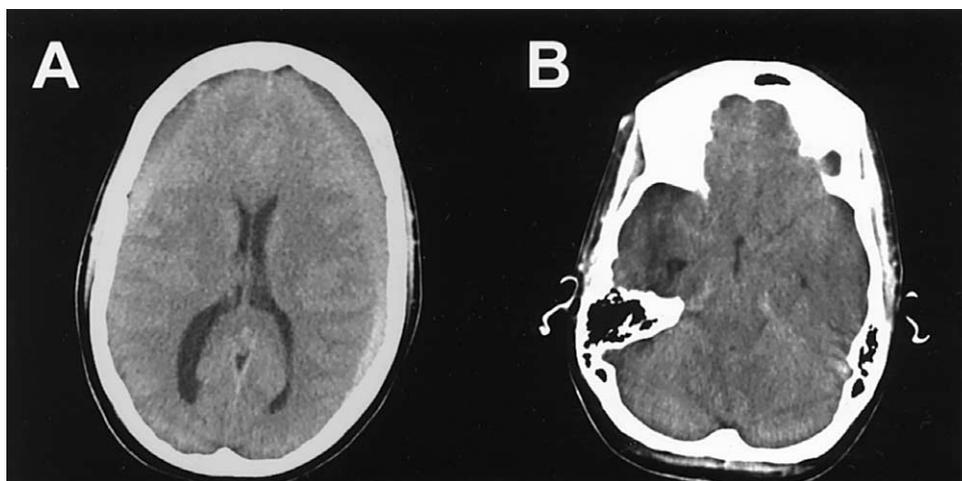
Computed tomography scan of the head showing bilateral chronic subdural hematomas at the convexity of both hemispheres (A). The chronic subdural hematoma appears as a mixture of hypo- and hyperdense material corresponding to hemorrhages of different ages. The adjacent cortical sulci are compressed. As a result of bilateral hematoma formation, there is no midline shift. The diminishing of the basal cisterns next to the brain stem (B) indicates increased intracranial pressure and movement of the brain caudally.
